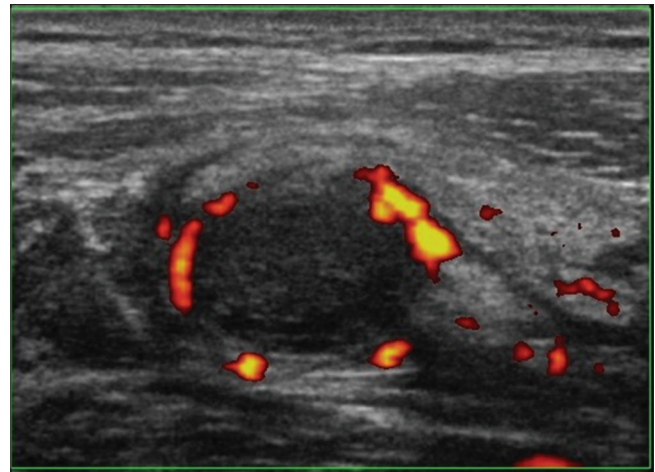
Transverse ultrasound image of appendix which appears enlarged, hypoechoic with surrounding fat stranding showing increased peripheral vascularity on power Doppler study suggestive of hyperemic blood flow around the inflamed appendix
